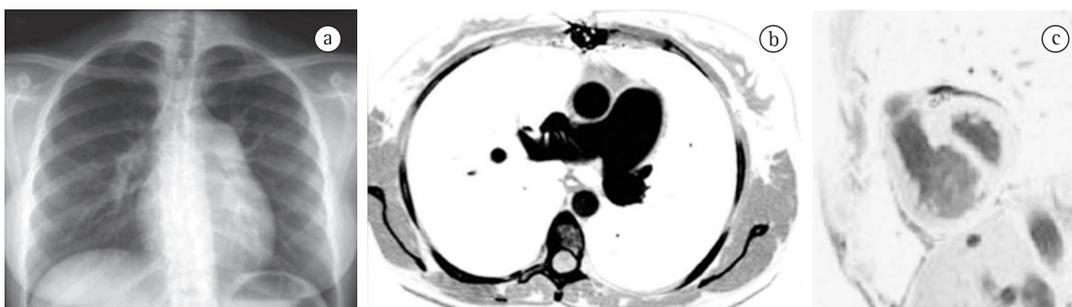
In a), chest X-ray of a 30-year-old patient with idiopathic pulmonary arterial hypertension showing hilar enlargement. In b), CT scan of the chest of a patient with pulmonary arterial hypertension showing a severely dilated pulmonary artery trunk (39 mm). In c), cardiac magnetic resonance imaging of a patient with pulmonary hypertension. Image without short-axis contrast showing the right ventricle (on the left) and the left ventricle (on the right). Note ventricular septal bowing leading to compression of the left ventricle.
